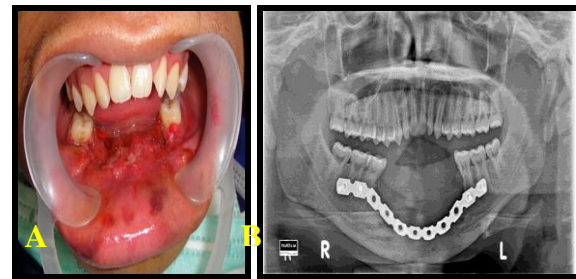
One month post operation. A. That the lesion had regressed, there was neither wound dehissence nor any exposed AO plate. B. Panoramic X-ray showed the bone plate was attached too
